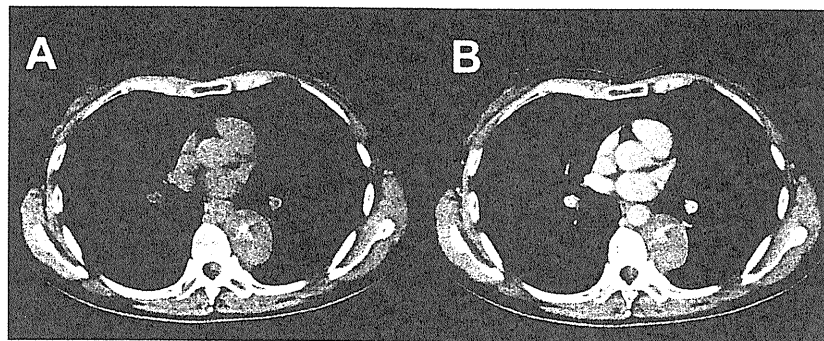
A: Chest CT showing a well-delineated tumor in the left parasvertebral space. B: The tumor contained calcification with heterogeneous and weak enhancement.
